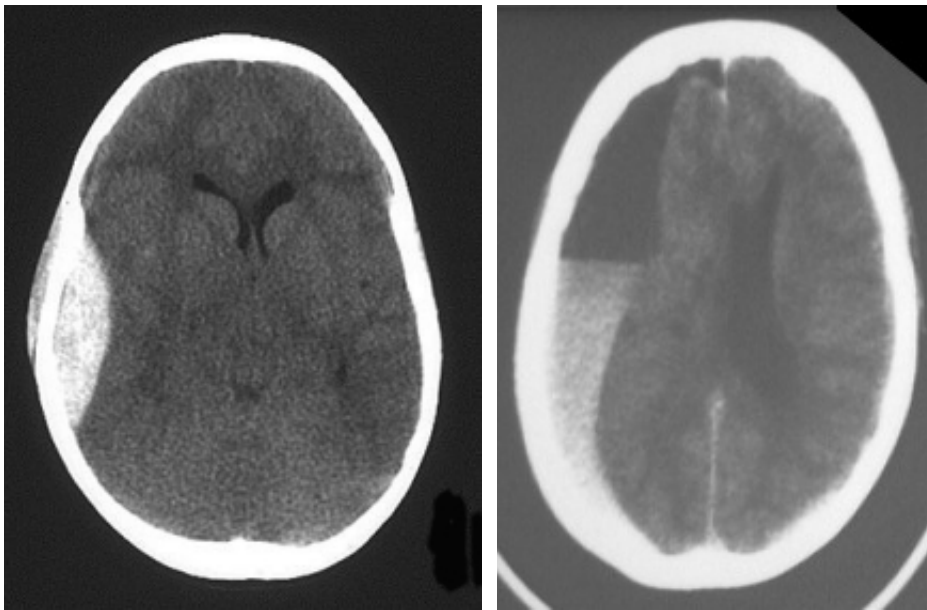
CT scan appearances of a extradural (Left) and subdural (right) haematoma
